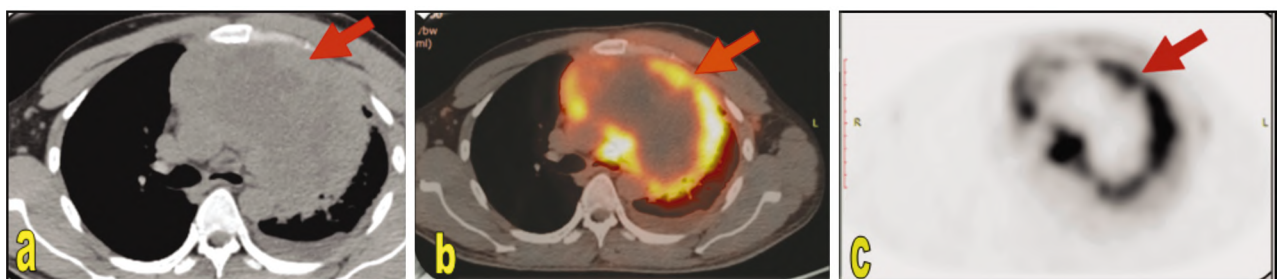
PET CT study for Male patient 30 year old presented with Dyspnea, persistent fatigue & unexplained weight loss. Axial CT Chest with fused PET images (A,B,C) showing large well defined heterogeneous soft tissue mass lesion seen implicating the anterior mediastinum more at the left side with increase FDG Uptake SUVmax=14.5 (Arrowed). It is inseparable from the mediastinal structures with large central photopenic area of necrosis. PET/CTDiagnosis:malignant looking lesion. Pathology revealed: B-cell lymphoma.
